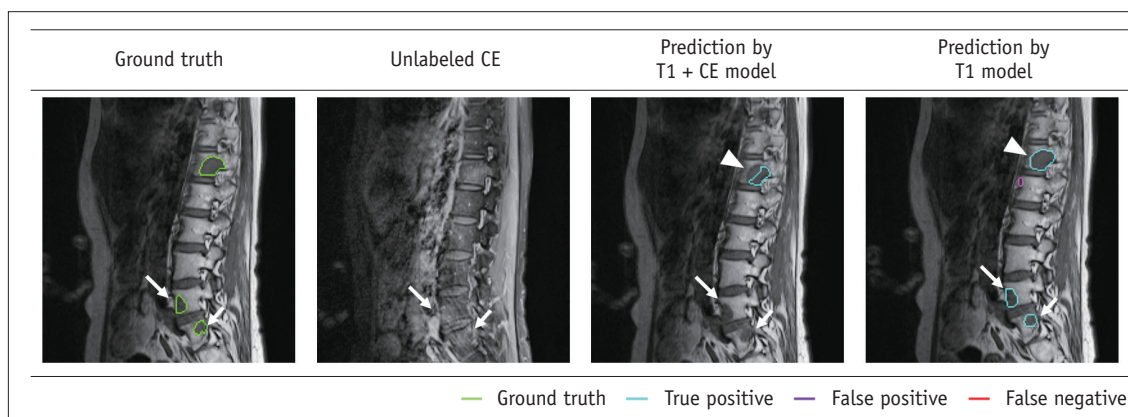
Images of a 54-year-old female diagnosed with colon cancer. The metastases at L5 and the S1 vertebral bodies (arrows) were predicted by the T1 model, while the T1 + CE model missed both the lesions, showing faint enhancement on the CE. The T1 model also showed better segmentation prediction of another detected lesion (arrowheads) than that by the T1 + CE model. T1 = non-contrast T1-weighted image, CE = contrast-enhanced fat-suppressed T1-weighted image
